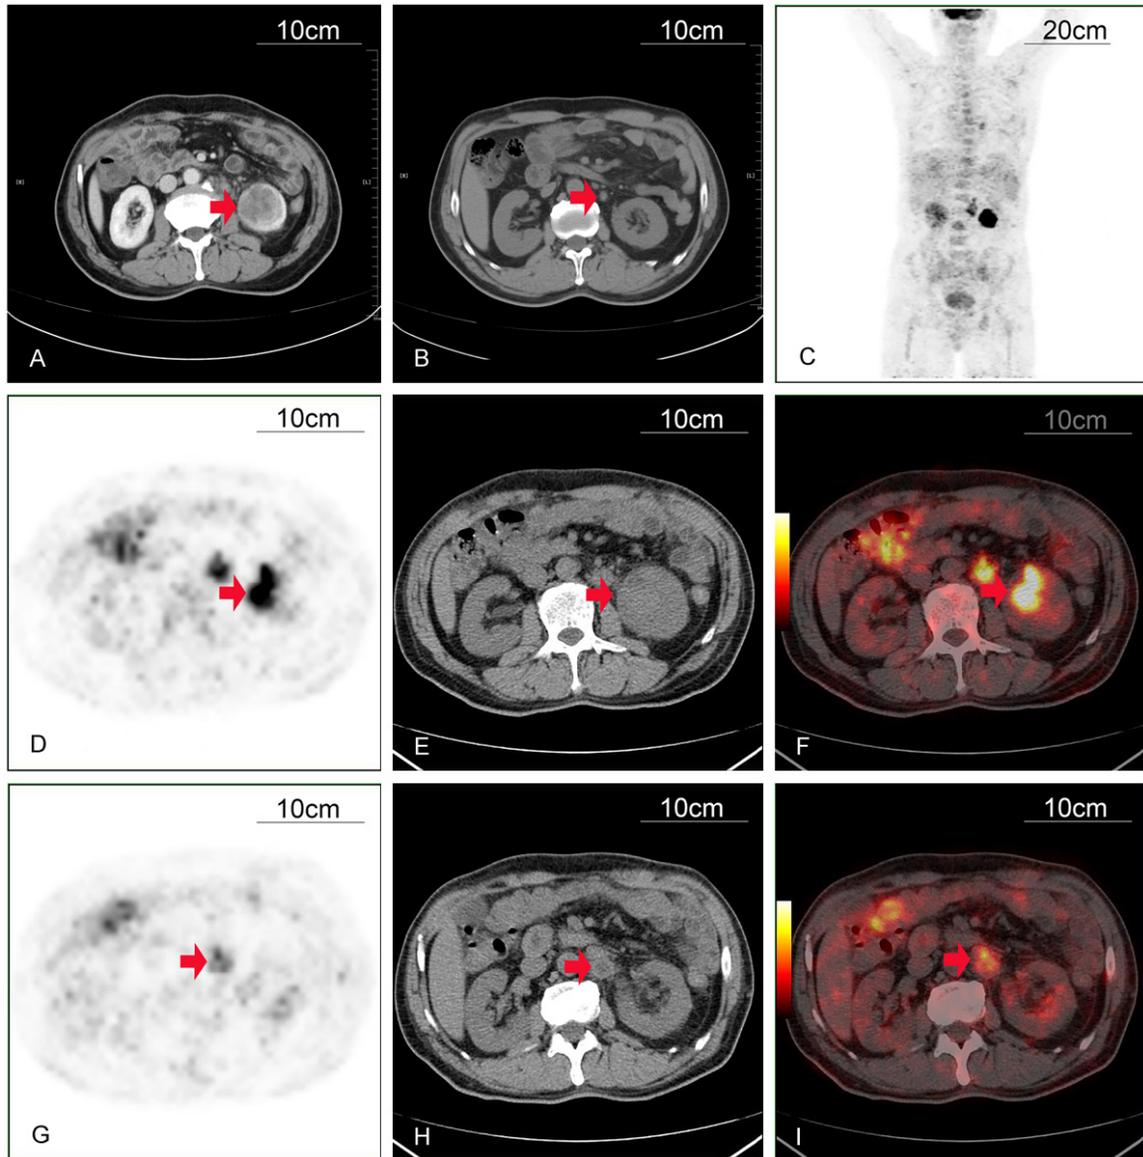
CT and PET-CT scan images of metastatic tumor in the left kidney and retroperitoneal lymph nodes. Sixty four-slice CT scan image of metastatic tumors of left kidney (A) and further enlarged retroperitoneal lymph nodes 11 months after esophagectomy (B). PET-CT scan images of body (C), a left renal metastatic tumor (D-F) and metastatic retroperitoneal lymph nodes (G-I) with significantly increased uptake of ^{18}F -FDG.
